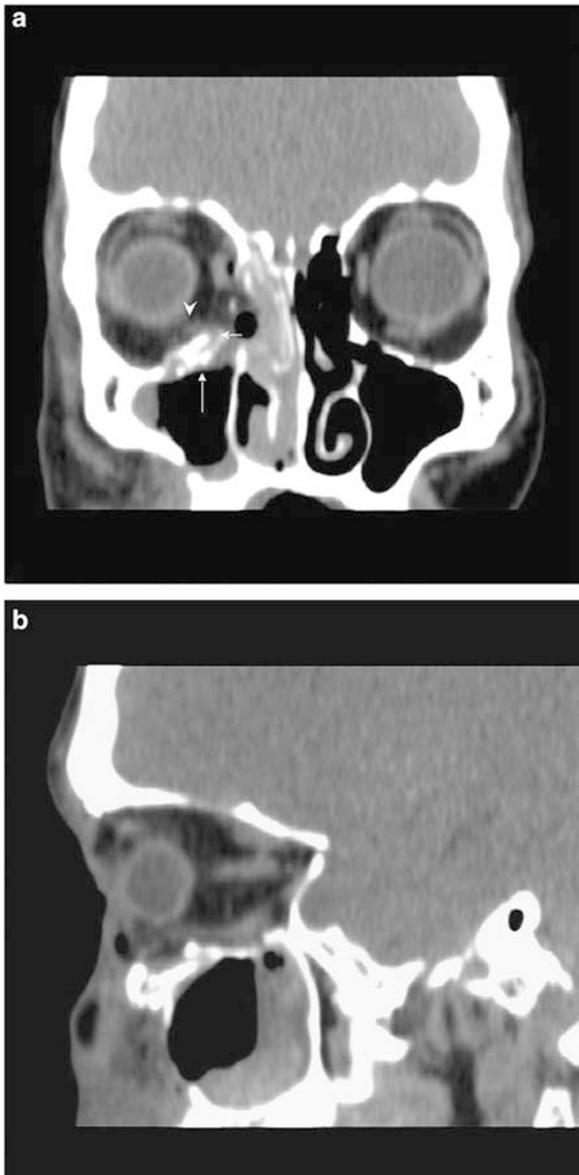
(a) A coronal CT scan of the same patient after Foley balloon catheterization demonstrating stretching of the inferior rectus muscle (arrowhead) toward the orbital floor fracture (short arrow) abutting bone fragments (long arrow). (b) A sagittal CT scan after Foley balloon catheterization showing a disrupted course of the inferior rectus muscle in the orbit and stretching toward the orbital floor fracture ('deflection sign'). Orbital floor exploration disclosed entrapment of the inferior rectus muscle sheath within the orbital floor fracture.
